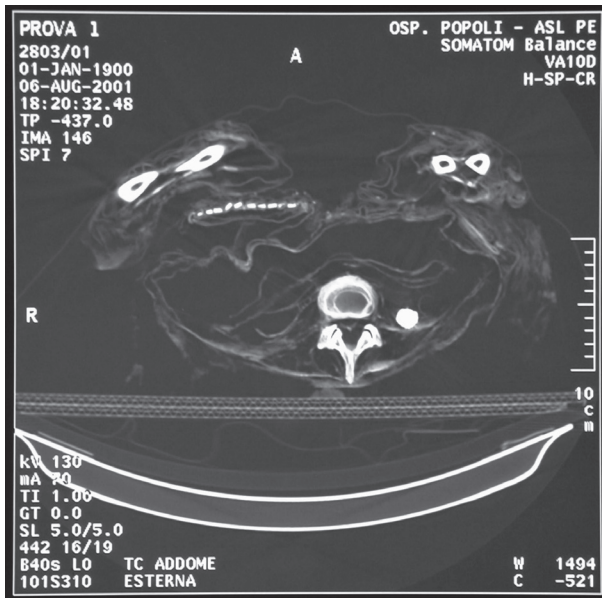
CT scan showing the stone and the metal artifact.
